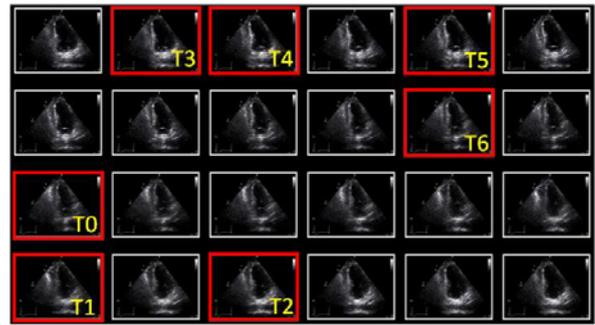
Show selected individual steps of echocardiography
